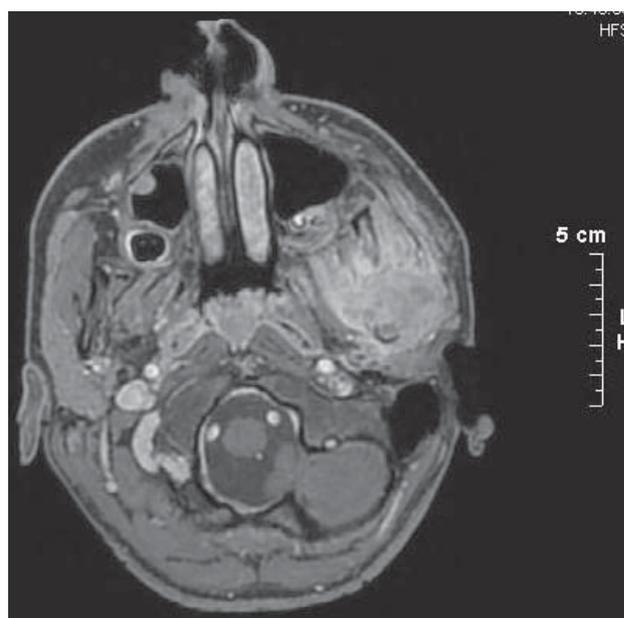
Case 1: MRI showing a 4.7 cm mass in the left infratemporal region
